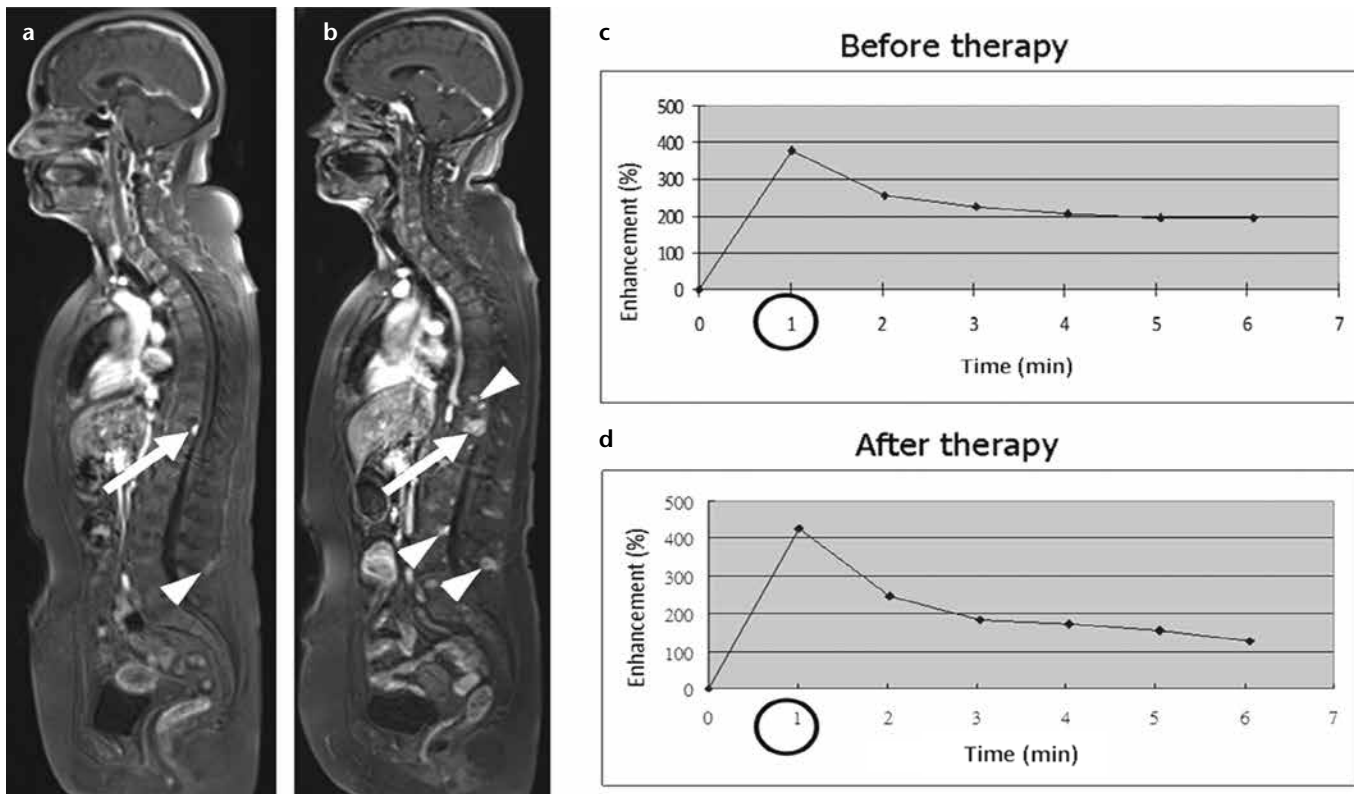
a–d. A 63-year-old female with multiple myeloma. Before autologous stem cell transplantation, the M-protein IgA level was 37 g/L (images not shown). Subsequent analysis showed an M-protein IgA level of 0 g/L, consistent with a complete response according to international criteria. However, the whole-body dynamic contrast-enhanced MRI (a) shows multiple active focal lesions demonstrating early enhancement (arrow and arrowhead). Two months later, progression of these focal lesions is obvious on this dynamic contrast-enhanced MRI (b, arrow and arrowheads). The maximum focal lesion enhancement was recorded at 1 min postinjection before (c) and after (d) therapy.
